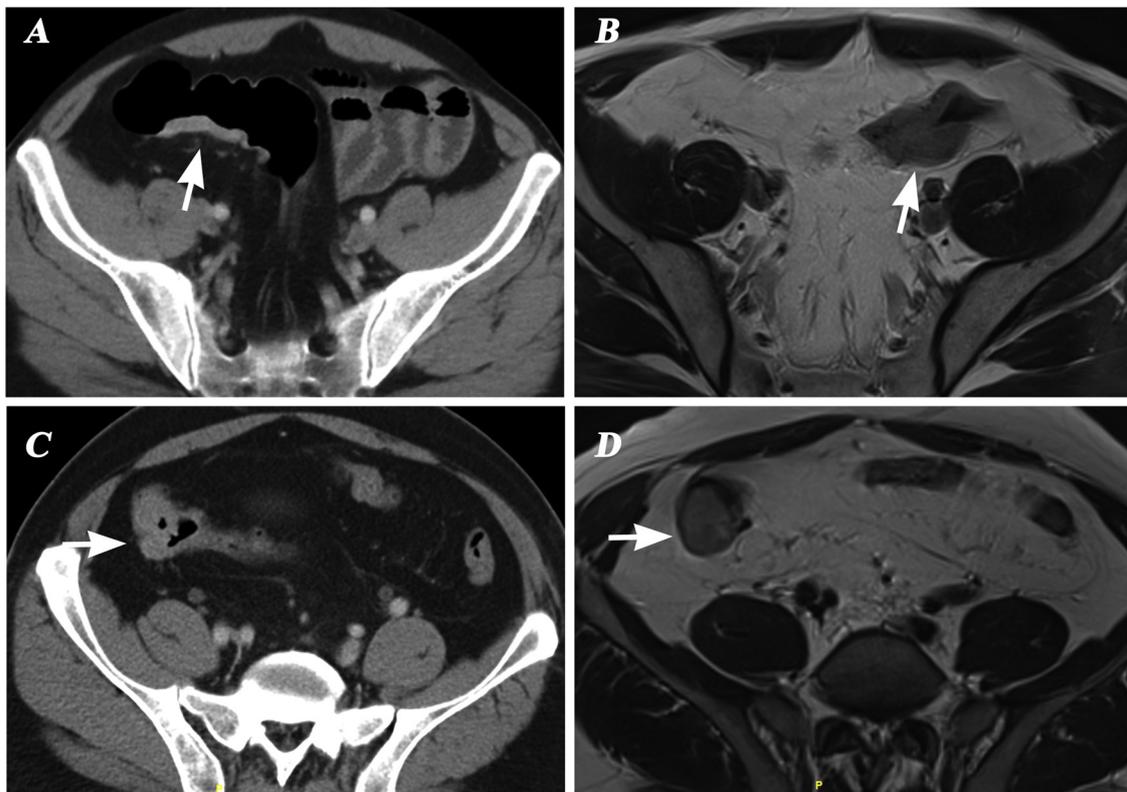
A–B: Pathologically proved stage T3 colon carcinoma. Axial post-contrast CT (A) shows the smooth outer margin representing a T1-2 disease (subjective score of 1, under-staged), but Axial T2-weighted imaging (B) accurately displays the absence of the muscular layer as T3-4 disease (score of 3). C–D: Pathologically proved stage T2 colon carcinoma. Axial post-contrast CT (C) shows mildly coarse outer margin as T3-4 disease (score of 3, over-staged), while axial T2-weighted imaging (D) correctly displays the low signal of muscular layer as T1-2 disease (score of 0).
